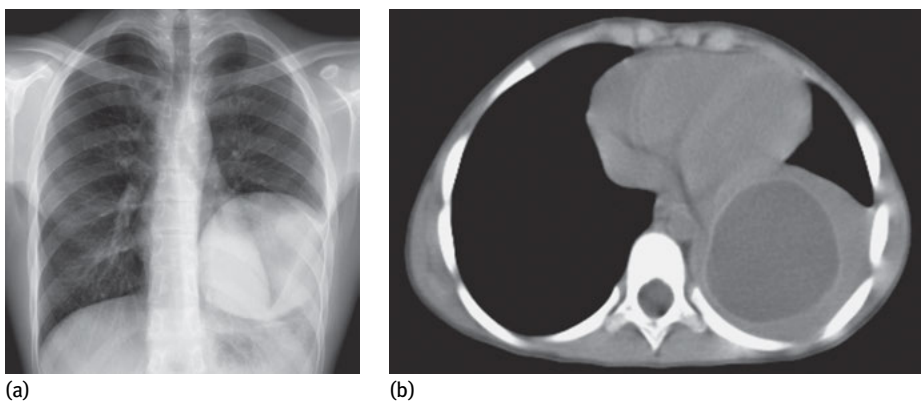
(a): Chest radiograph showing a well-defined, circular opacity surrounded by normal lung tissue in the left lower lung lobe (CE1 stage). (b): A computed tomography scan demonstrating a large solitary cyst and atelectasis in the pericystic lung tissue (CE1 stage).
